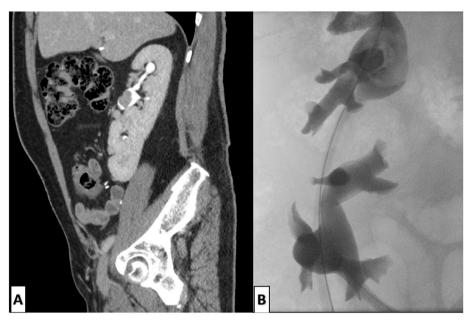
(A) Computed tomography of the abdomen, sagittal view, demonstrating crossed fused kidneys, the upper portion representing the orthotopic right kidney with the left kidney fused to its inferior pole. (B) Retrograde pyelography demonstrating the collecting system of each kidney.
